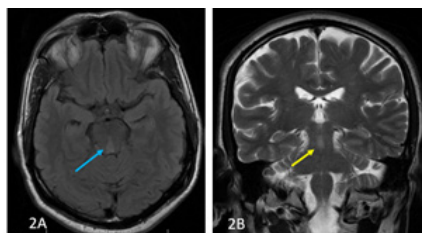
Axial FLAIR (2A) and coronal T2 (2B) MRI brain images showing hyperintense lesion in bilateral paramedian midbrain.
